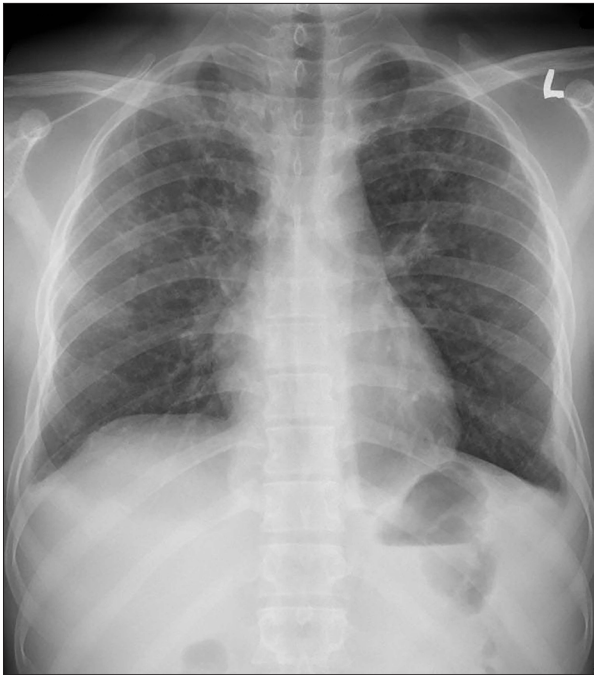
Chest X-ray showing bilateral infiltrates, mainly in the upper zones.
